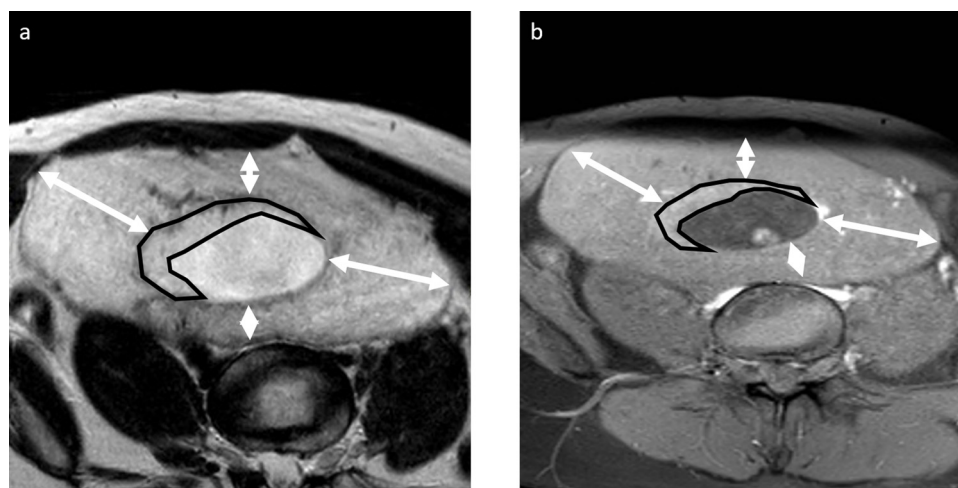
Magnetic resonance imaging. T2-weighted image (a) and T1-weighted image (b) with inversion recovery in the axial plane of the uterus at 10 weeks of gestation. Diffuse T2 hyperintense and T1 slightly hyperintense (compared to muscle) myometrial thickening with T2 and T1 hypo-intense irregularities (White arrows in a and b). The placenta can be seen on the right side with anterior extension (black free form).
